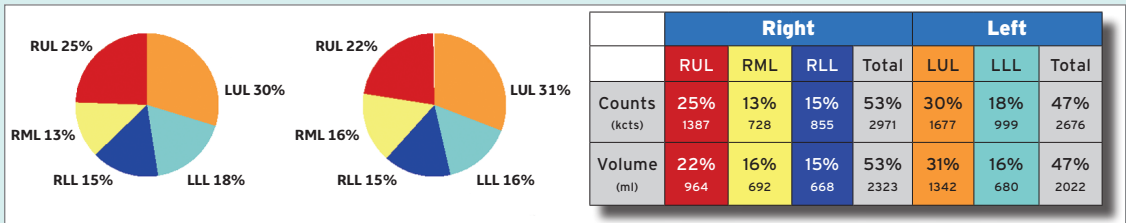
Accurate quantitation in a 13 sec/step, 15 min SPECT acquisition. Perfusion: 220 MBq of ^{99m}Tc MAA; 20-60 mAs, 120 kV, ASiR 50%. Ventilation: 40 MBq of ^{99m}Tc Technegas; 20-60 mAs, 120 kV, ASiR 50%.
